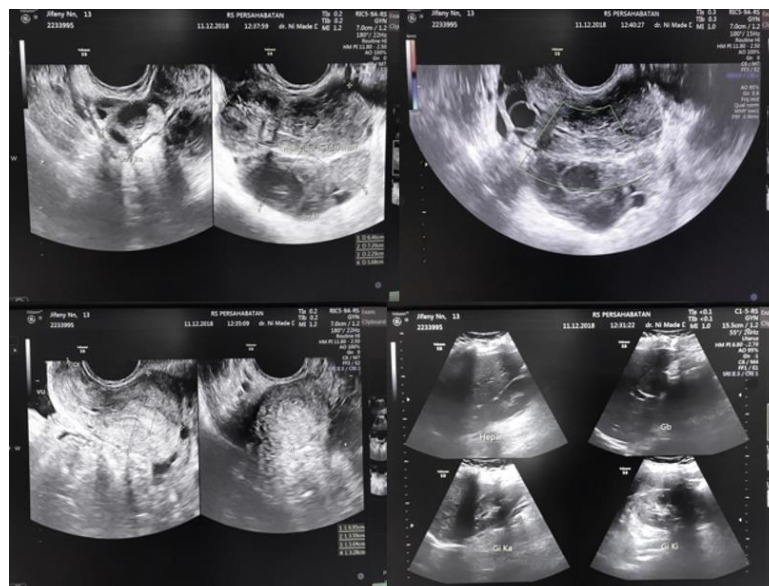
Ultrasound findings (transrectal)
